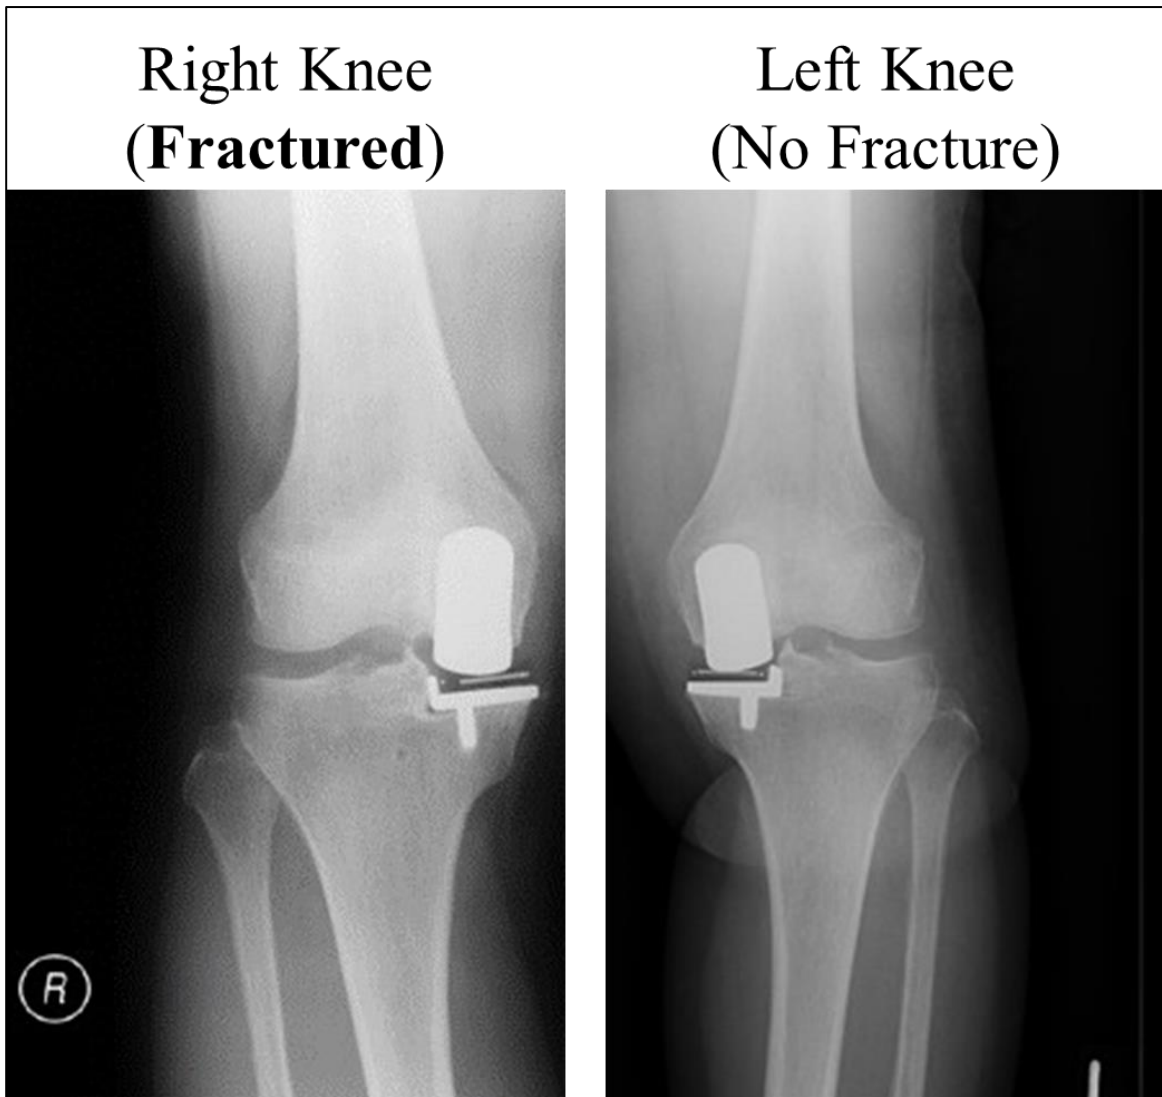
Post-operative anteroposterior radiographs of the right and left knees of Case 2. The right knee had a tibial periprosthetic fracture, while the left knee has had no complications to date.
